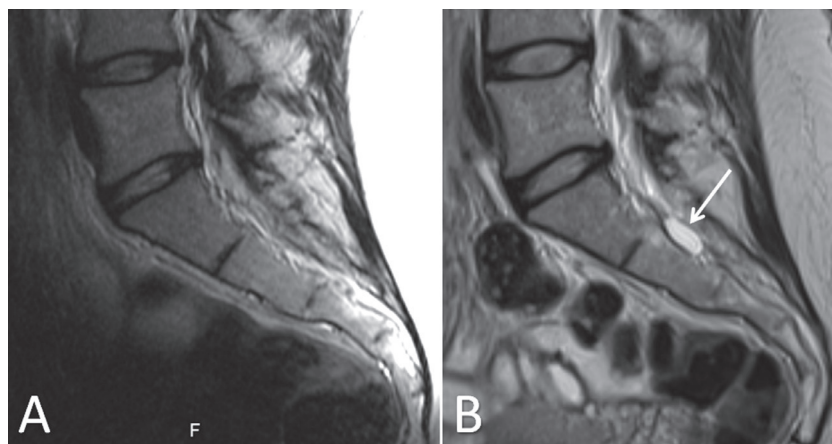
MRI of a female patient with MFS, 20 years old at baseline, who has developed herniation of a nerve root sleeve. (Left) sagittal T2 at baseline. No herniation seen. (Right) sagittal T2 at follow-up. A nerve root sleeve herniation has become evident (arrow).
